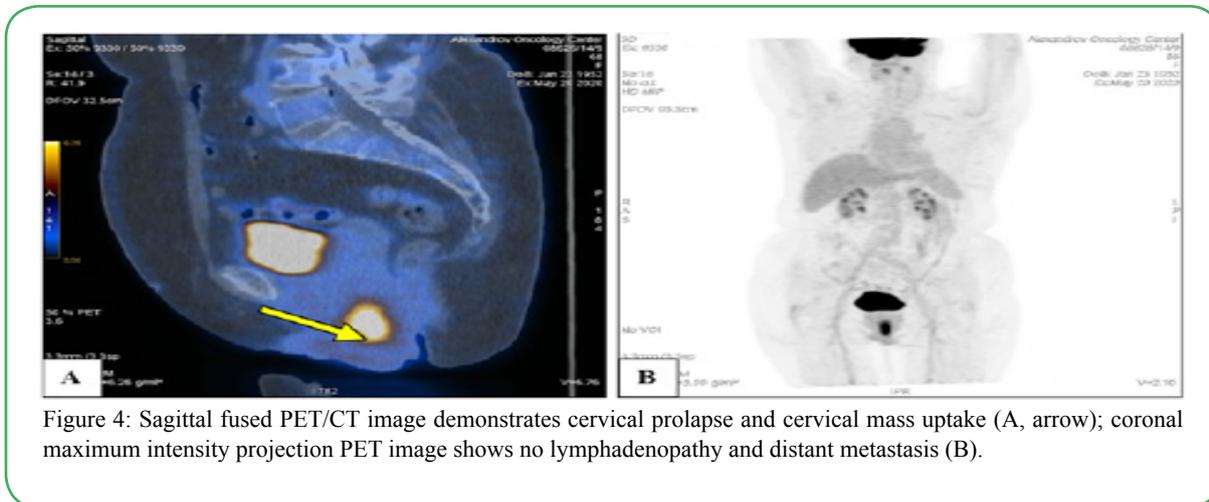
Sagittal fused PET/CT image demonstrates cervical prolapse and cervical mass uptake (A, arrow); coronal maximum intensity projection PET image shows no lymphadenopathy and distant metastasis (B).
